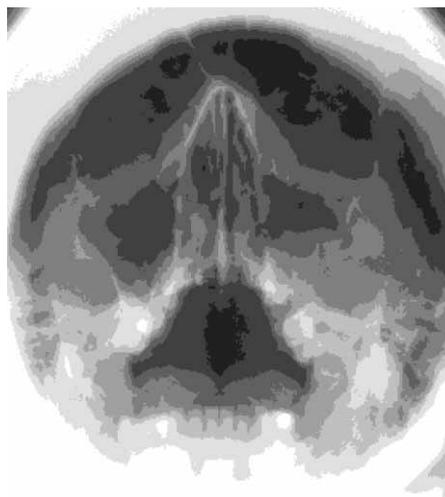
Unicystic radiographic appearance of the ameloblastoma, extending to the maxillary sinus and destroying the anterior and lateral sinus walls which mimic radiographic appearance of the mucocelle.
